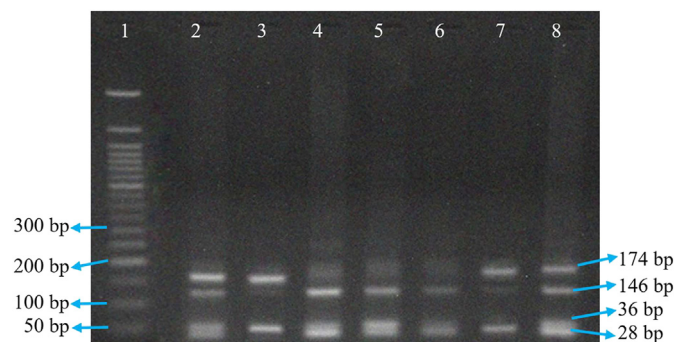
Restriction endonuclease (*BanII*) digestion fragments of *KCNJ11* rs5219 polymorphism (2% agarose gel). Lane-1: 50 bp molecular marker; Lanes 2 and 8: heterozygous (CT) form (28, 36, 146 and 174 bp); Lanes 3 and 7: mutant (TT) form (36 and 174 bp) and lanes 4, 5, and 6: wild-type (CC) form (28, 36 and 146 bp).
